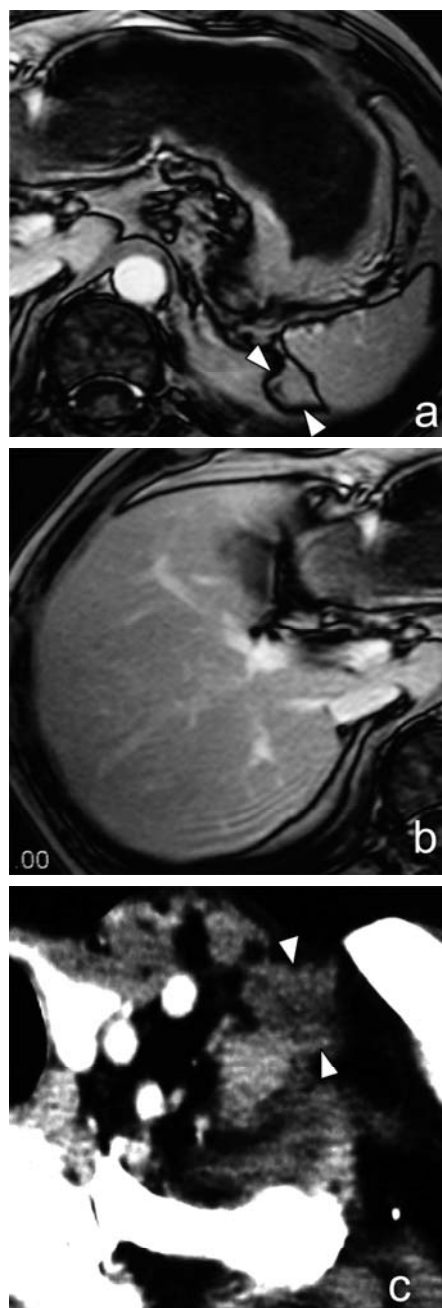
After 5 cycles of the first-line combination chemotherapy consisting of cisplatin, etoposide, and ifosfamide, MRI showed 95% volume reduction of the renal tumor (a) and a complete response of the liver metastases (b), and thoracic CT showed 50% volume reduction of Virchow's lymph node (c).
